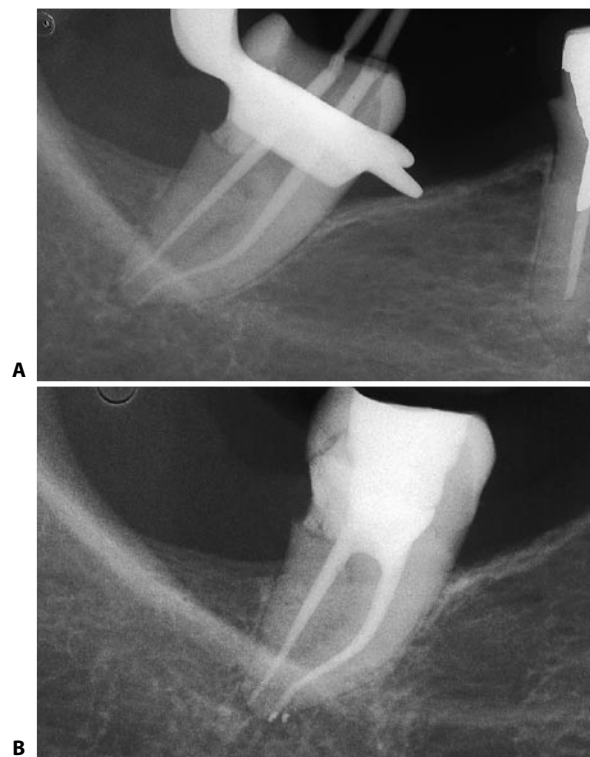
A. Intraoperative radiograph of the cone fit in a lower third molar: the canals are narrow and slightly curved; therefore, the cones are shortened by a fraction of a millimeter. B. Postoperative radiograph.
